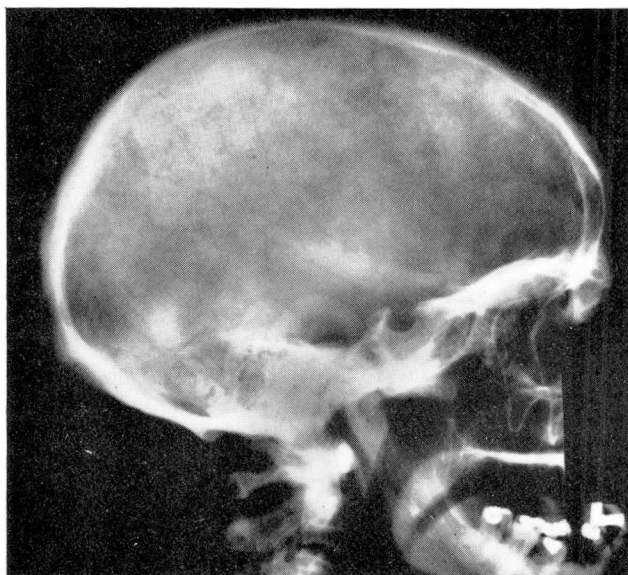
Roentgenogram showing the change of the base of the skull.
